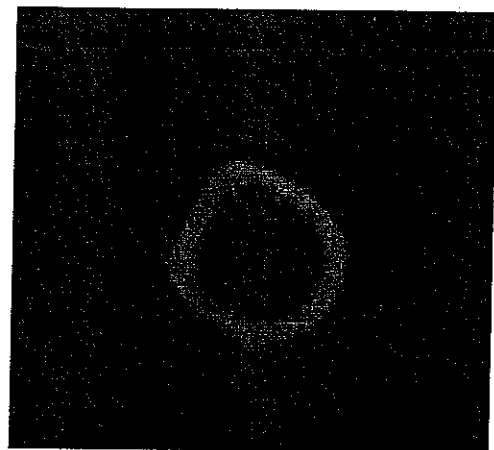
Axial CT image of the femur showing the interior margins of the bone as it does not exhibit the phenomena of occlusion.
